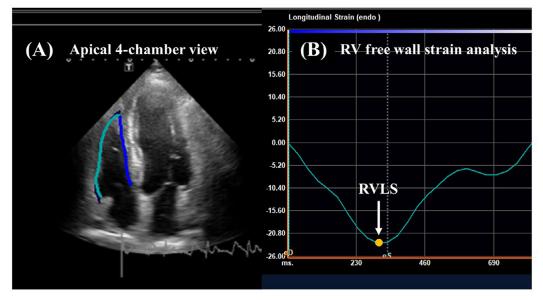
Measurement of free wall RVLS. Apical 4-chamber view used for the measurement of RV strain (A). RVLS was defined as the peak negative value of the strain curve during the entire cardiac cycle (white arrow; B). RVLS = right ventricular longitudinal strain.
